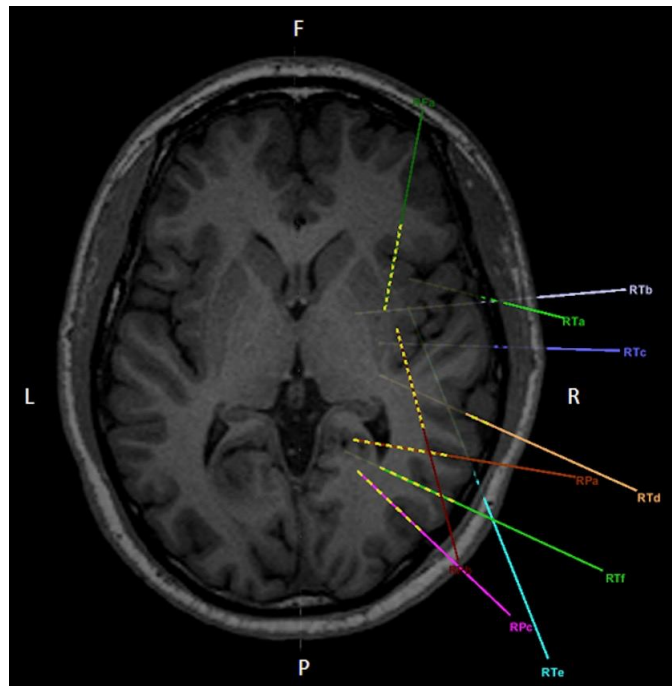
MRI-based 3D scheme of SEEG implantation: patient №8.
